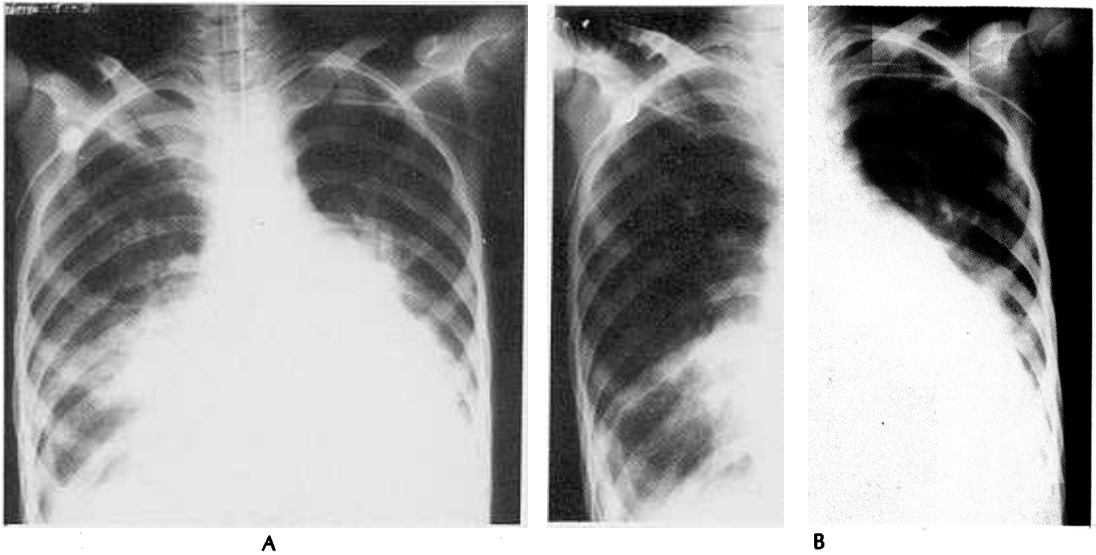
X-rays of chest A-P taken in patients with hemoptysis (A) and after fiberoptic bronchoscopy resolved haziness in the right lower lung field (B).
